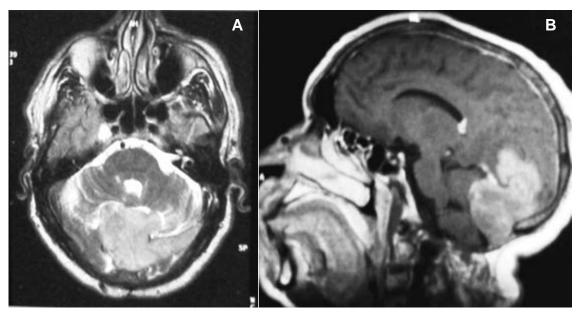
A) Axial MRI (at the recurrence), displaying a poorly circumscribed vermal mass with bilateral paramedian extension. B) Sagittal MRI (at the recurrence), demonstrating a poorly circumscribed hyperintense cerebellar lesion extending into the occipito-parietal lobes.
